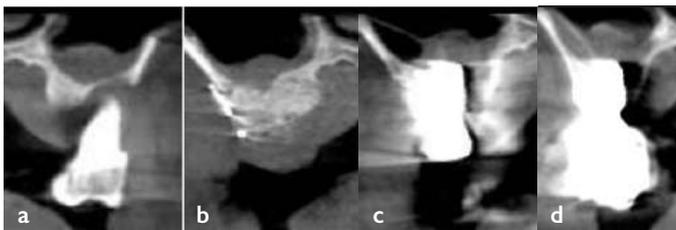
CT scans taken before extraction of tooth #16, after socket preservation, after implant placement, and after completing the final restoration, respectively
